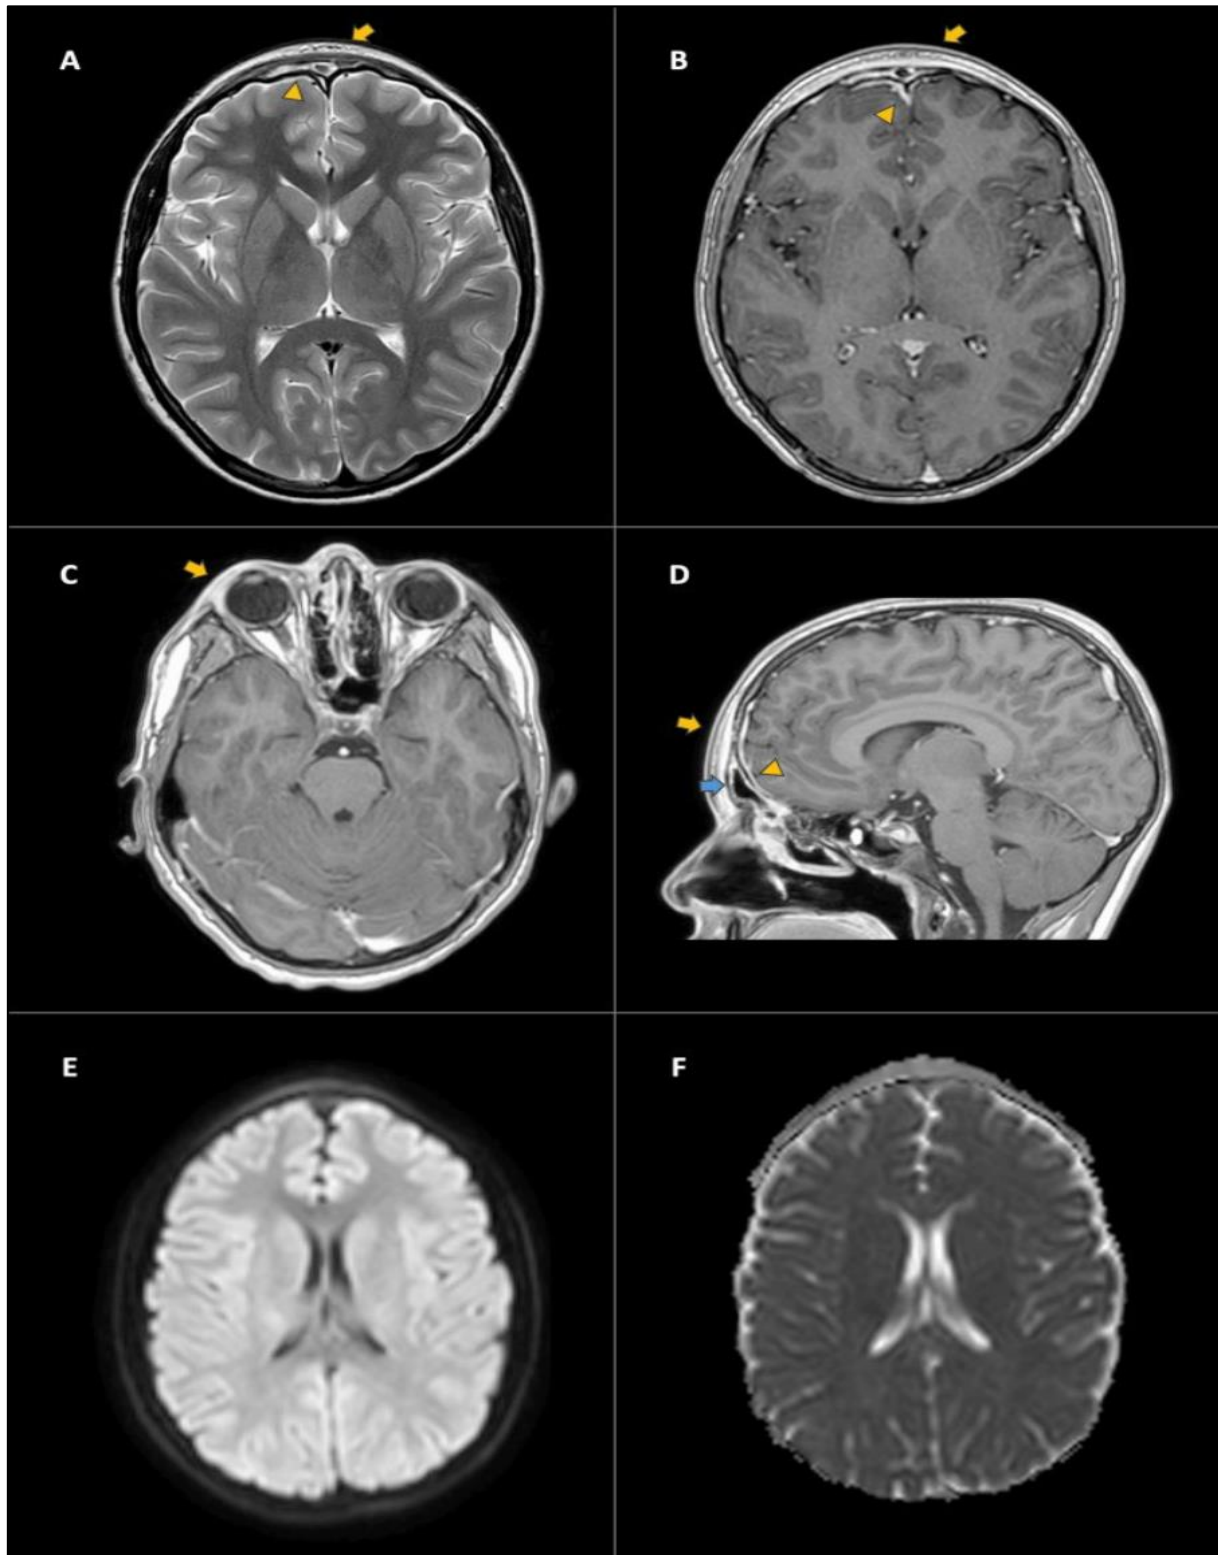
Contrast-Enhanced MRI of the Skull (Control).
